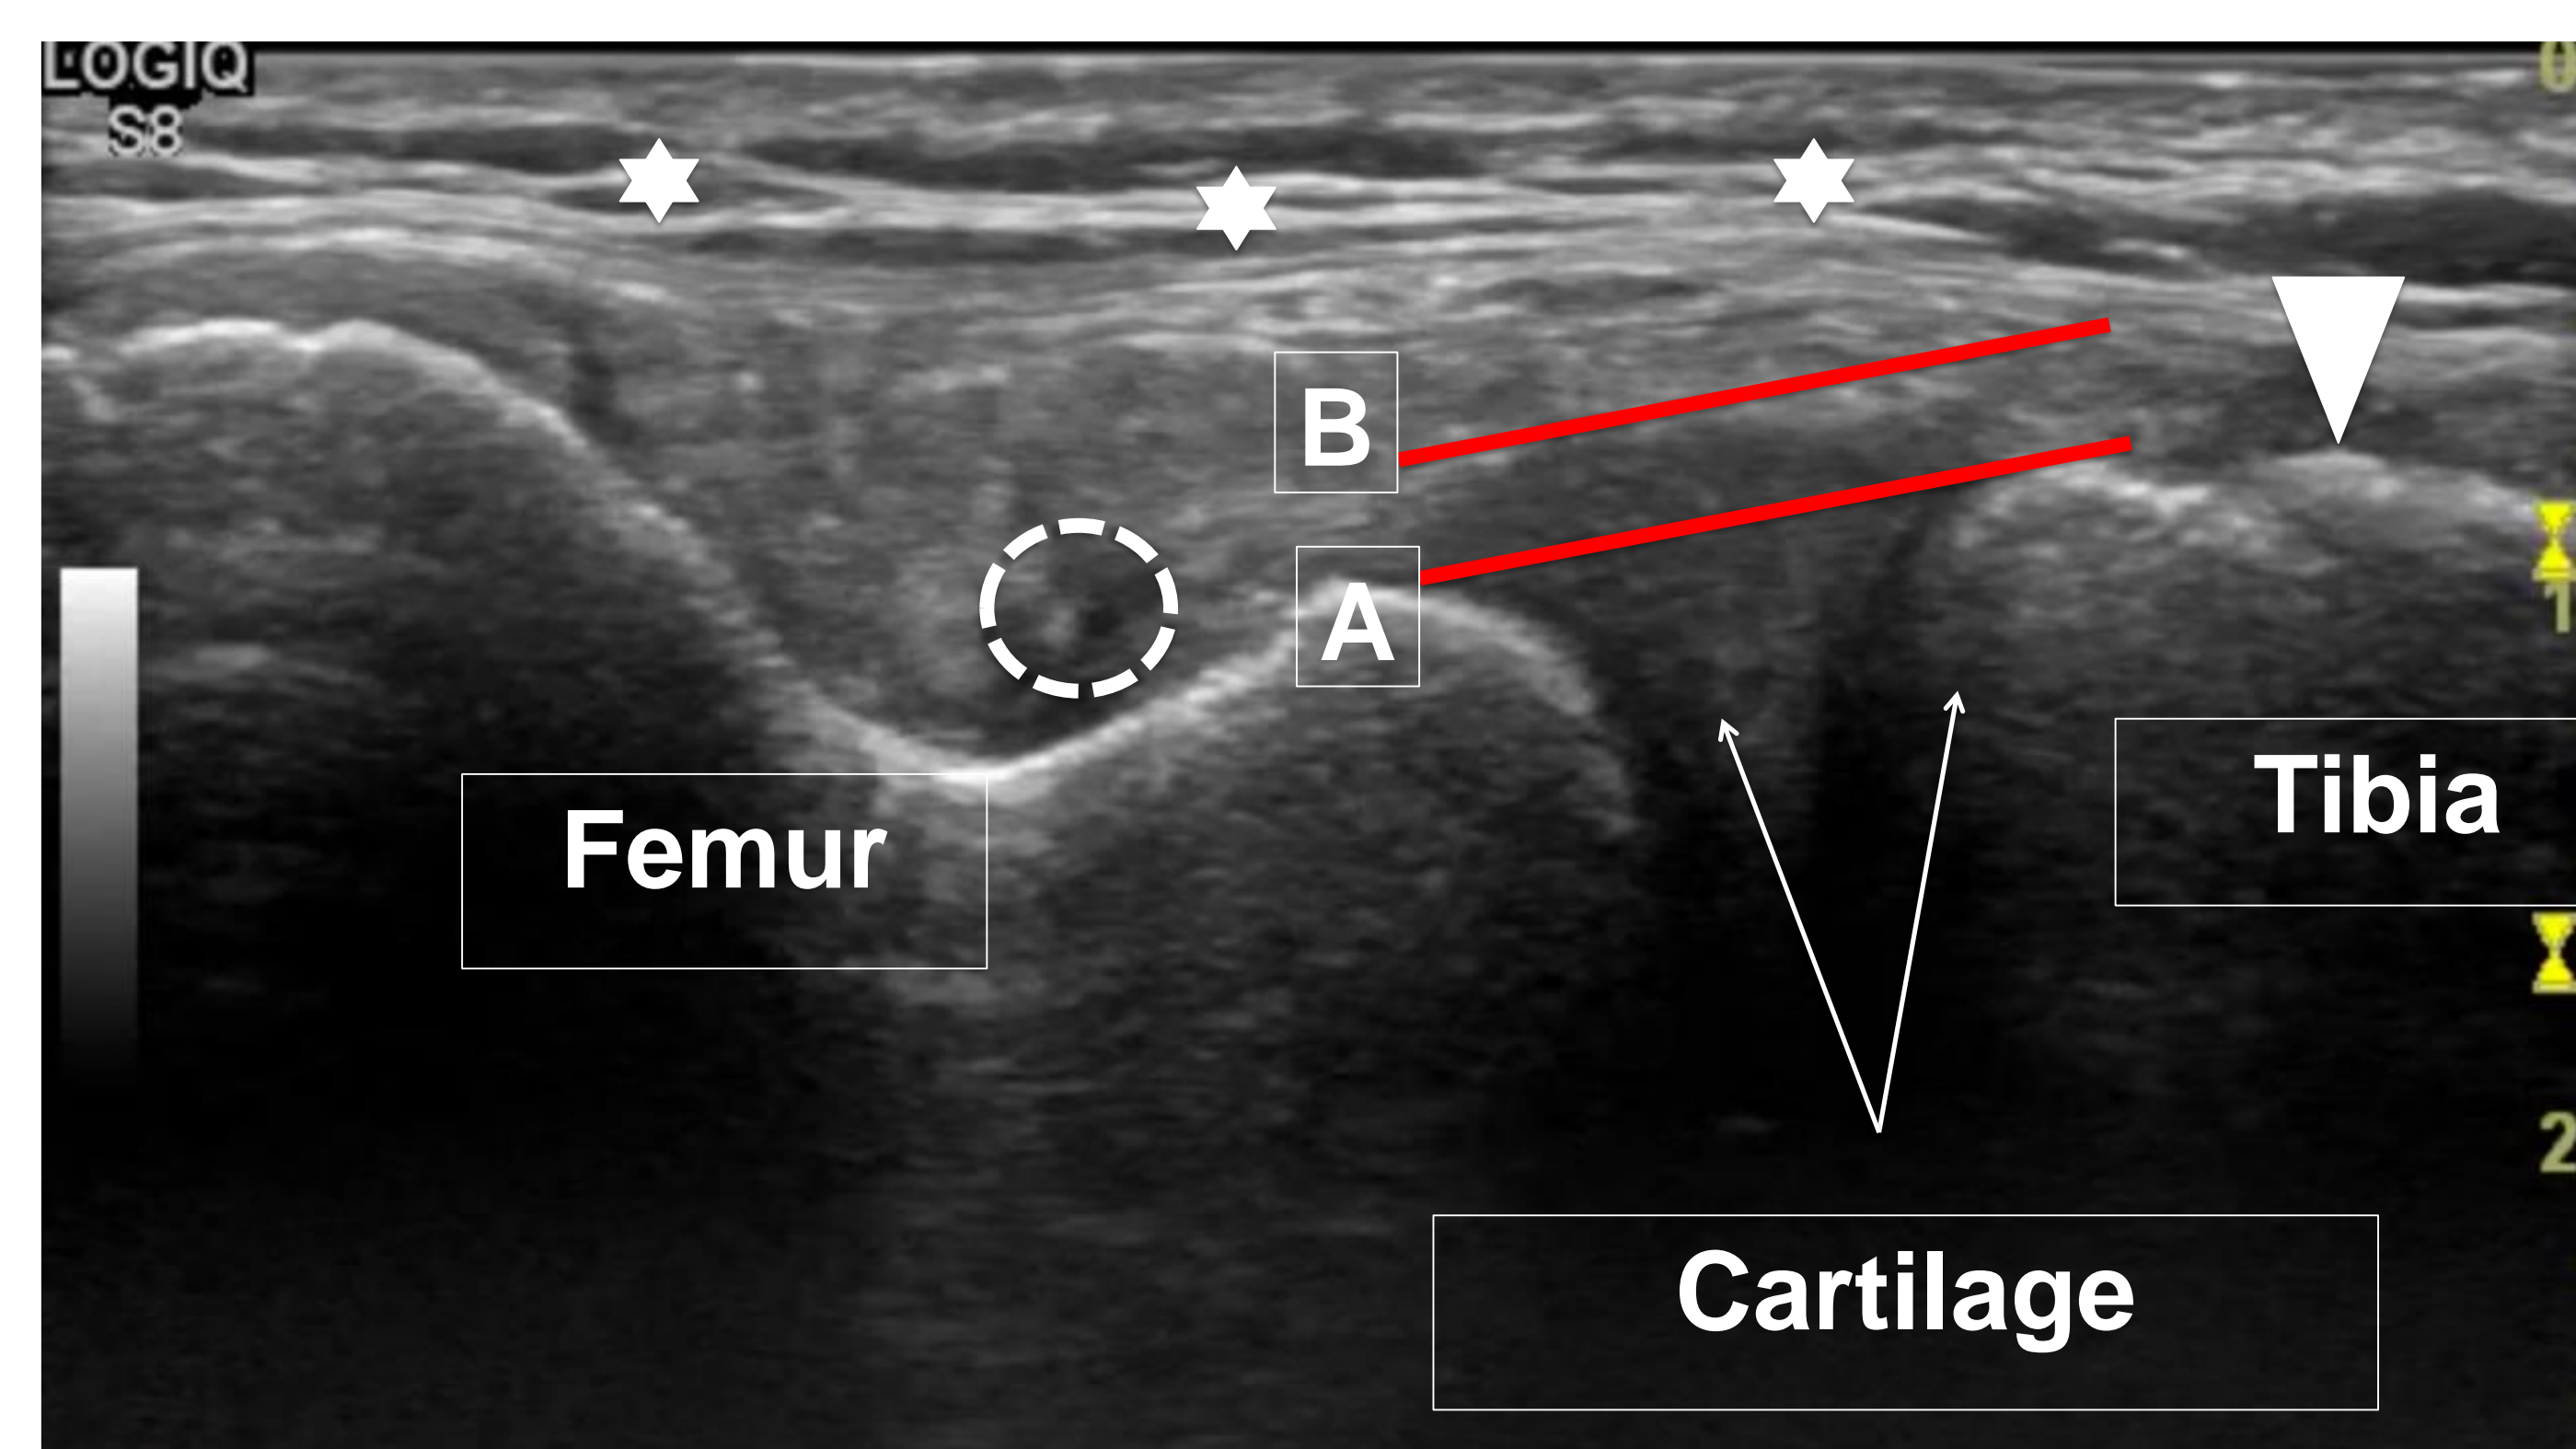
Ultrasound image of intact lateral meniscus
